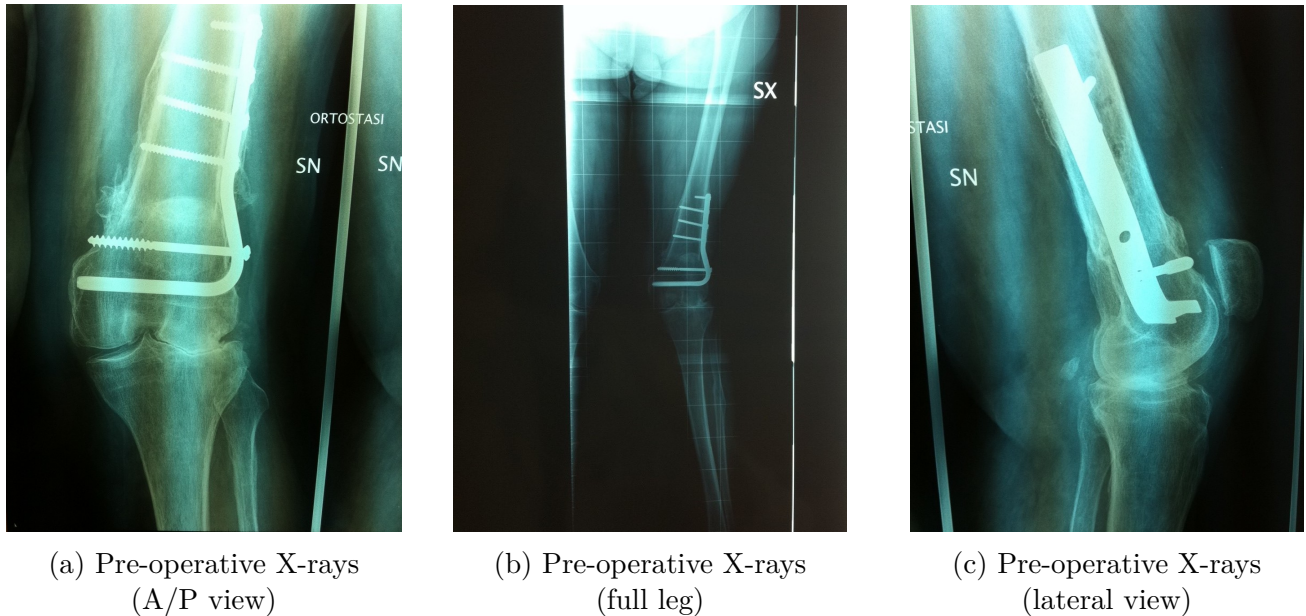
Patient's pre-operative X-rays. These pictures were obtained in the courtesy of *Gianluca Castellarin*
